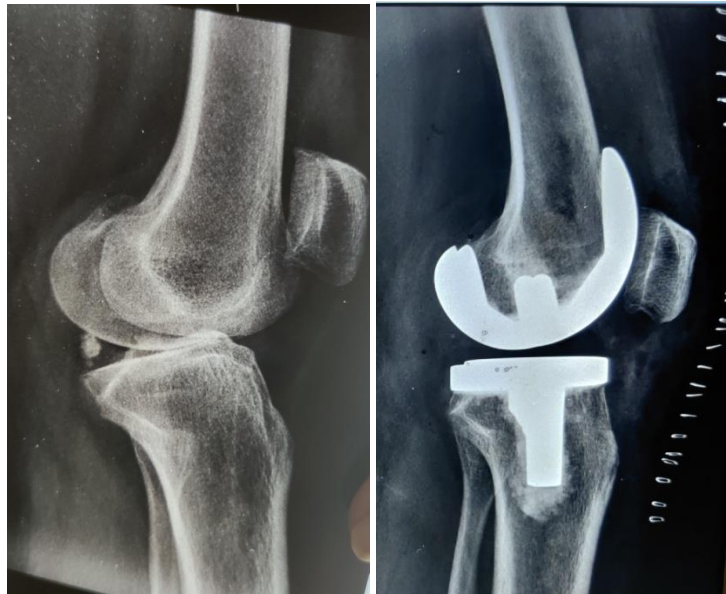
Pre-operative and post-operative X-rays of Case 1 for calculation of angles
